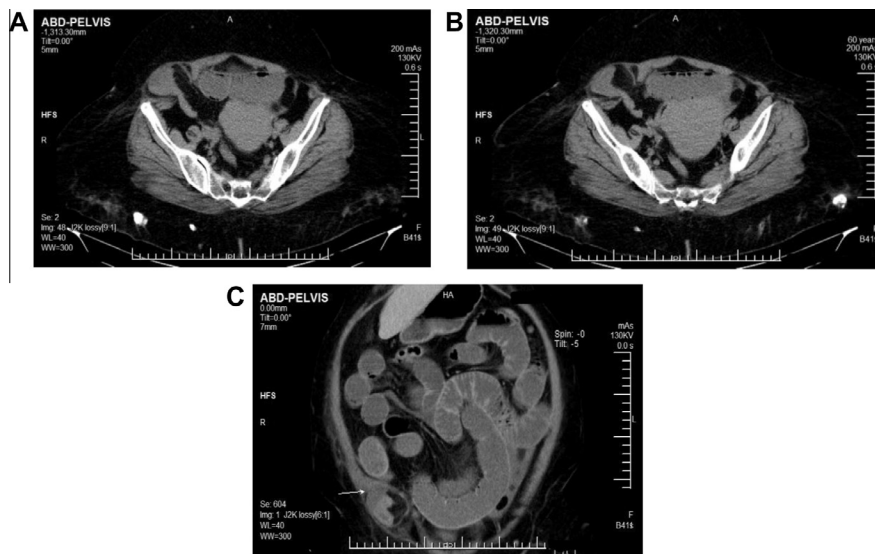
(A and B) 60-year-old female with a 3-day history of crampy abdominal pain, nausea, and vomiting. Axial MDCT scan obtained with IV and oral contrast agents shows dilated small bowel and collapsed colon. Note dilated bowel in region of speglian hernia (*arrow*). (C) 60-year-old female with a 3-day history of crampy abdominal pain, nausea, and vomiting. Coronal CT reformation of MDCT scan shows bowel dilatation throughout abdomen. “Knuckle” of bowel (*arrow*) passes through speglian hernia where there is an abrupt change in caliber. At surgery, incarcerated bowel within speglian hernia was reduced.
